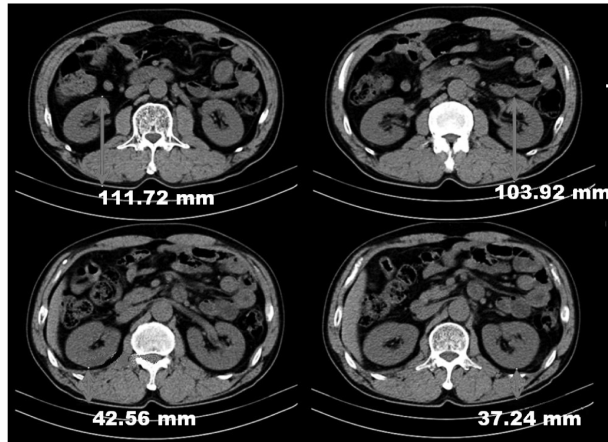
Selected CT images for averaging kidney depth. All CT images were reviewed and selected manually.
